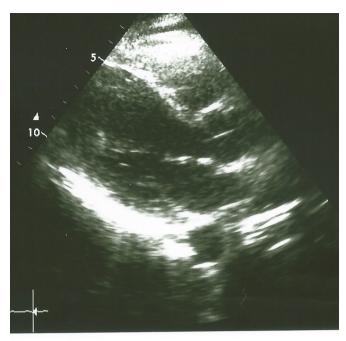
Transthoracic echocardiogram. (A) Long left parasternal axis with dilated left ventricle, hypercontractility of basal segments of the posterior wall and IVS. The remaining segments are hypokinetic. (B) Apical plane: apical dilation. Hypercontractility of basal wall segments lateral and IVS. IVS, inter ventricular septum.
